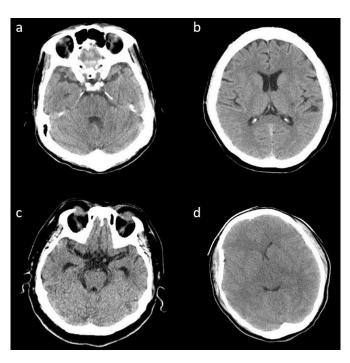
CT images of four patients who had an abnormal CT report. (a) The brain CT report revealed a suspected cerebellar infarct. Refer to patient 1 in Table 3. (b) CT report revealed a suspected small infarct. Refer to patient 2 in Table 3. (c) CT report revealed a lacunar infarct and a possible left middle cerebral artery aneurysm at M1 segment. Refer to patient 3 in Table 3. (d) CT report revealed cerebral edema and increased intracranial pressure. Refer to patient 4 in Table 3.
